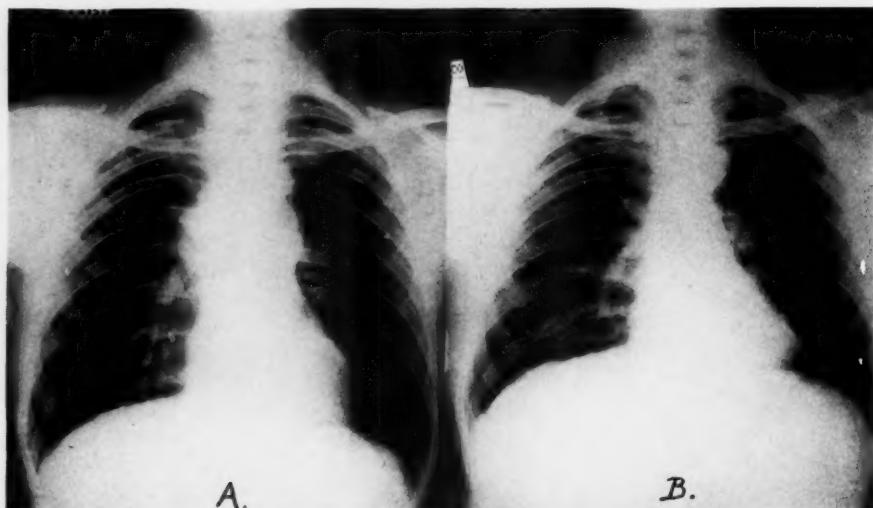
(A) Roentgenogram of chest on admission, May 11, 1934, showing large tumor mass in upper mediastinum. (B) Roentgenogram of chest taken November, 1935, showing complete regression of the mass. At necropsy no neoplastic cells, living or necrotic, were found in the mediastinum.
